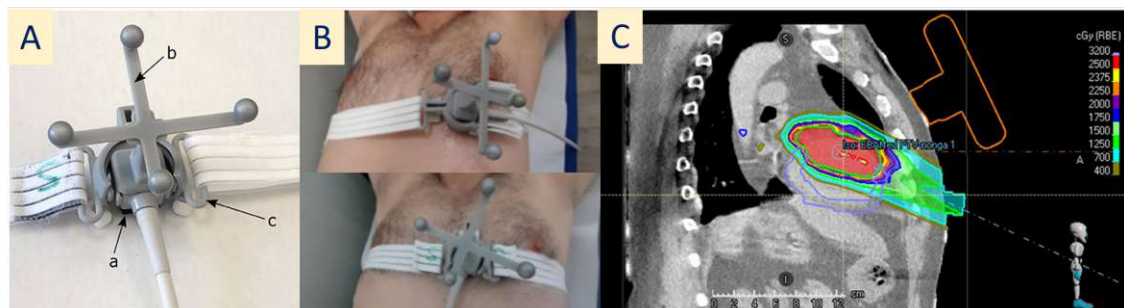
Panel A shows the EBAMed ultrasound prototype, panel B shows the two different placements of the probe for data acquisition and panel C shows the treatment planning system with the target and contour that accounts for the probe on the chest of the patient for treatment delivery [92, 93].
